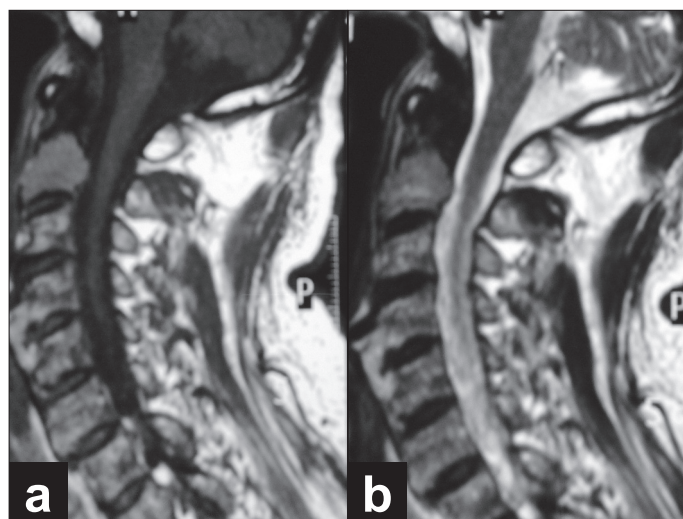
Magnetic resonance imaging scan of the cervical spine (sagittal section) showing the dysplastic of axis body. MRI demonstrated hypointensity on both T1 [a] and T2 [b], with minimal contrast enhancement
